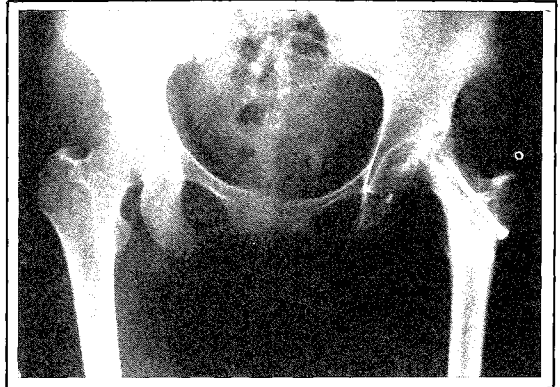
A post-operative radiograph Case 1. Left hip after osteotomy had united, fixed angle plate removed and cancellous screws inserted to protect the osteoporotic neck. A well corrected neck shaft angle is shown.
